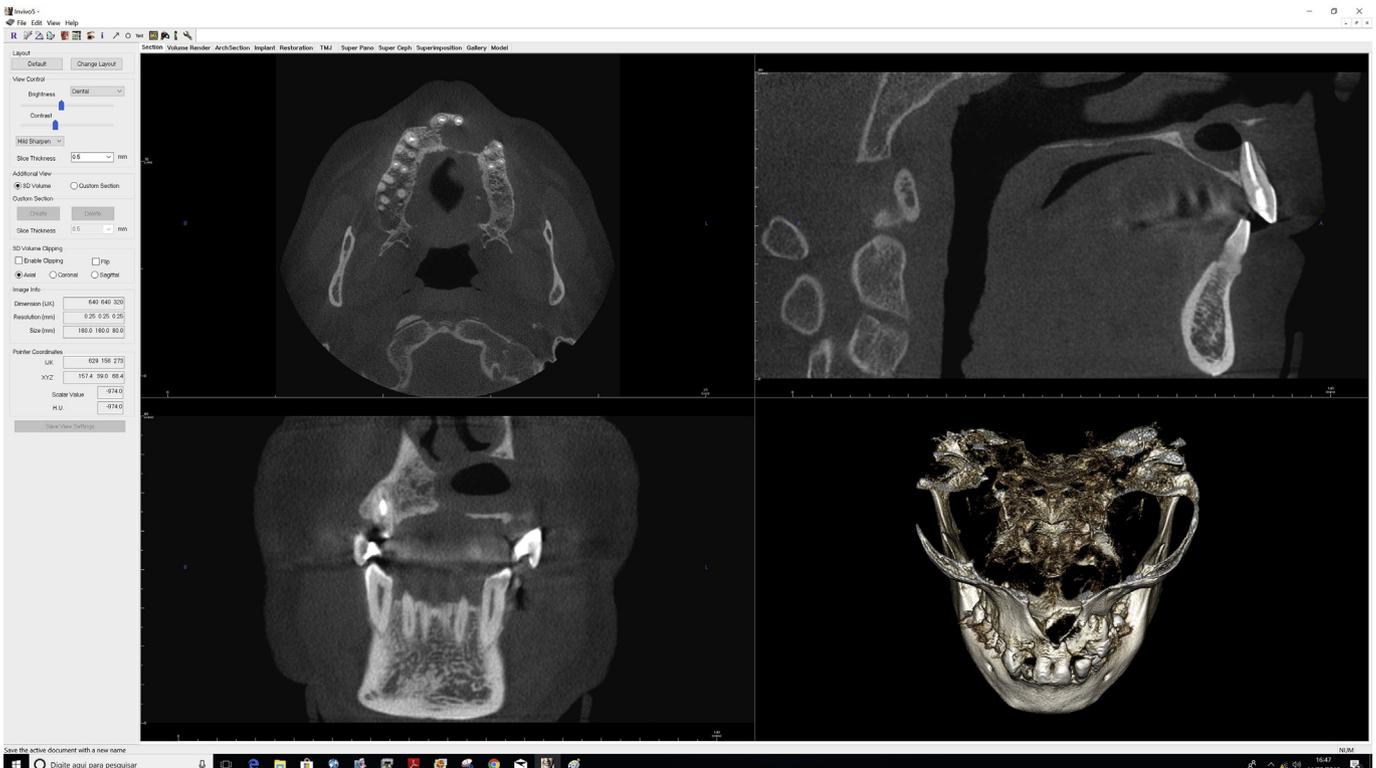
(CBCT of the same case shown in Fig. 1) exemplify the agreement regarding the indication of surgical treatment by the three examiners.
